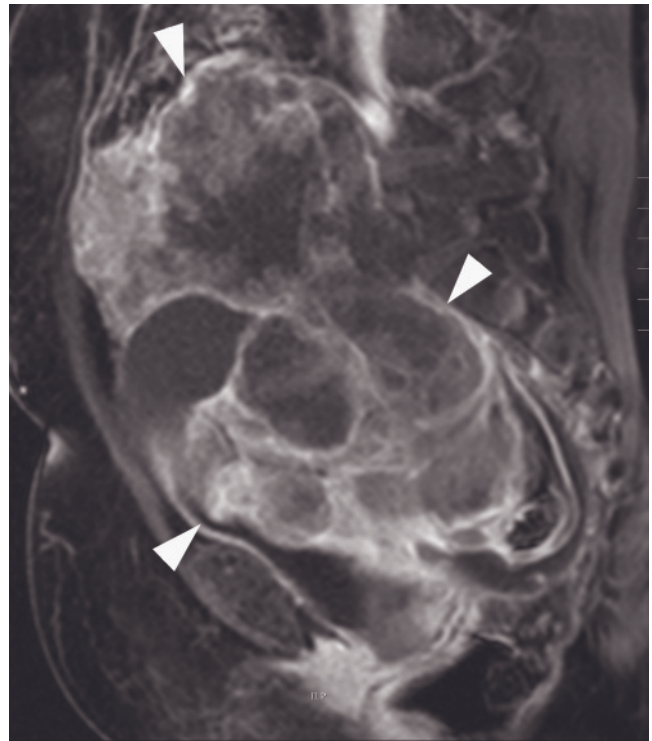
Recurrent granulosa cell tumor. Sagittal (a) and transverse (b) T2-weighted SS-ETSE and sagittal (c) and transverse (d) gadolinium-enhanced fat-suppressed T1-weighted gradient-echo images in a patient treated for granulosa cell tumor show a large, multiseptated mass (arrowheads). The septations and solid components enhance on postgadolinium images (c, d).
